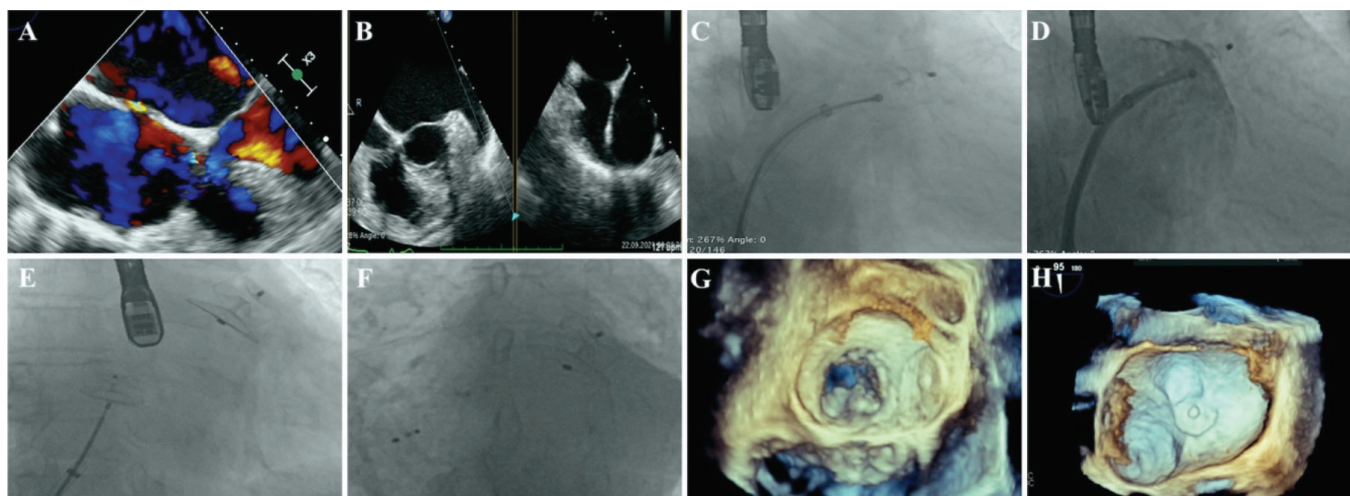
A) Transesophageal echocardiography with color Doppler showing a small shunt in the interatrial septum, consistent with a patent foramen ovale. B) Transesophageal echocardiography confirming the absence of thrombus in the left atrial appendage. C) Optimal positioning of the device was verified. D) Contrast imaging confirmed the absence of leakage. E) Implantation of the patent foramen ovale occlusion device. F) Confirmation of device positions. G, H) Follow-up transesophageal echocardiogram performed 45 days later showed no device-related anomalies in the patent foramen ovale and left atrial appendage positions
